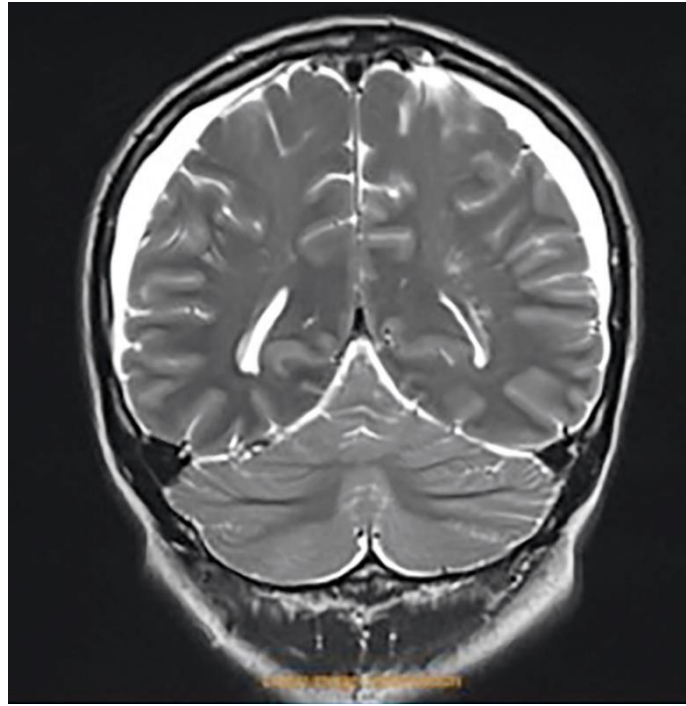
Cranial magnetic resonance imaging (MRI) of the patient.
